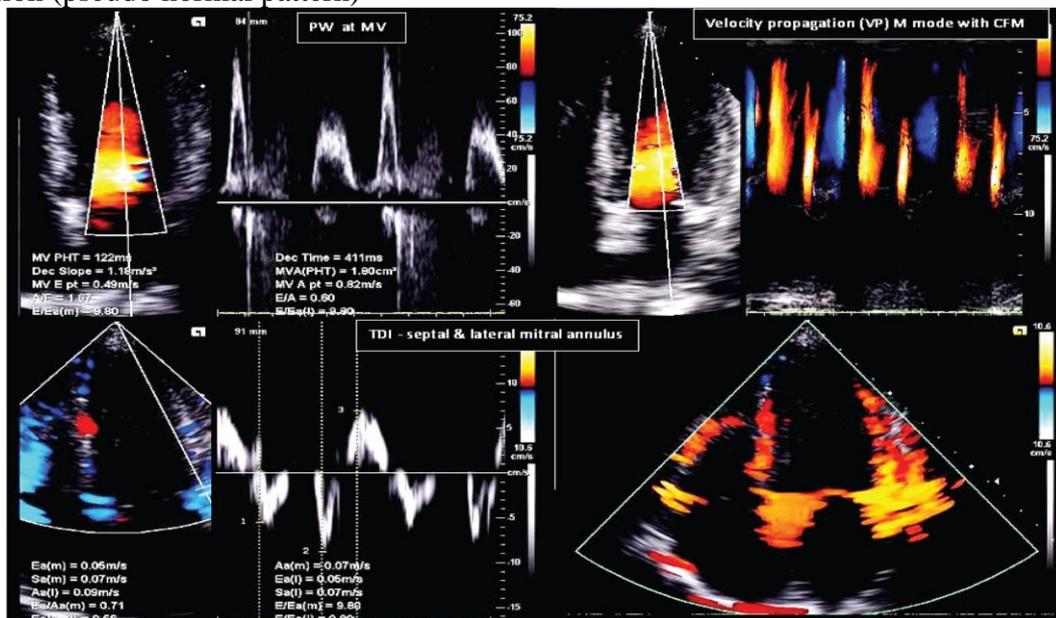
"A two-dimensional transthoracic echocardiographic evaluation" of "diastolic dysfunction" utilizes "pulse wave Doppler (PW)" at the "mitral valve", "velocity propagation" (VP) via "color 'M' mode", and "tissue Doppler imaging (TDI)" at the "septal and lateral mitral annuli".
